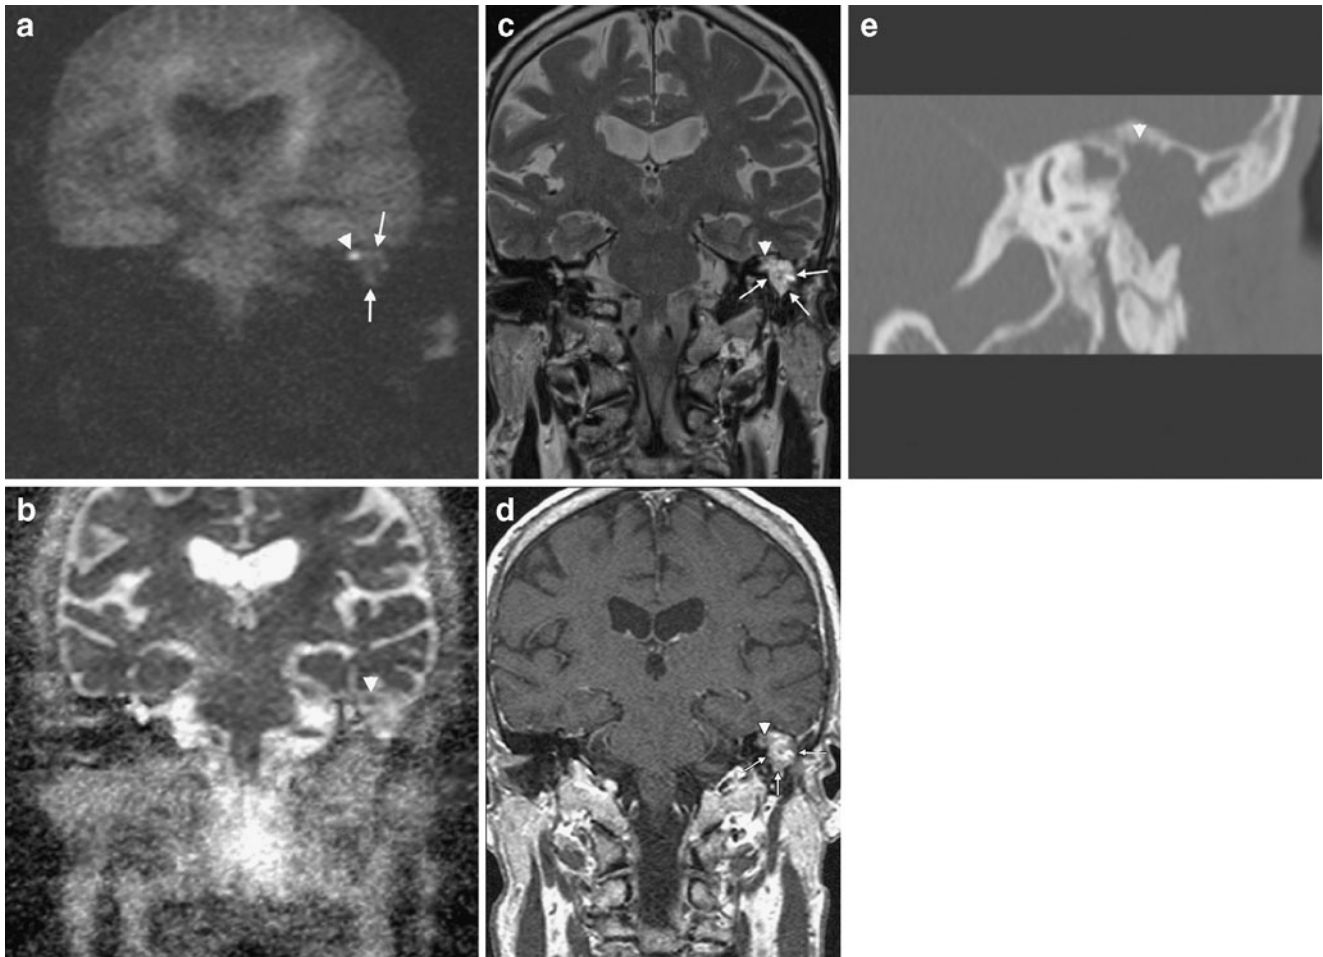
A 62-year-old female treated for middle ear cholesteatoma on the left side 15 months before. a Coronal non-EP DW b1000 image (SS TSE DW sequence or HASTE DW sequence). A small nodular hyperintensity (*arrowhead*) is seen under the medial part of the tegmen. Note the soft tissues lateral to this nodular hyperintensity, isointense with brain tissue (*arrows*). b ADC map, same level as a. Note the small nodular hypointensity (*arrowhead*). This small nodular hypointensity corresponds to the nodular hyperintensity in a. c Coronal 2-mm-thick TSE T2-weighted image, same level as a and b. The nodular lesion can be seen as a small nodule with moderate signal intensity (*arrowhead*) delineated by clear hyperintense material on its lateral and inferior side (*arrows*). Compared to a and b. d Coronal 2-mm delayed post-gadolinium T1-weighted image, same level as a, b, and c. The lesion can be depicted as a small nodular hypointensity (*arrowhead*) under the medial part of the tegmen. It is
